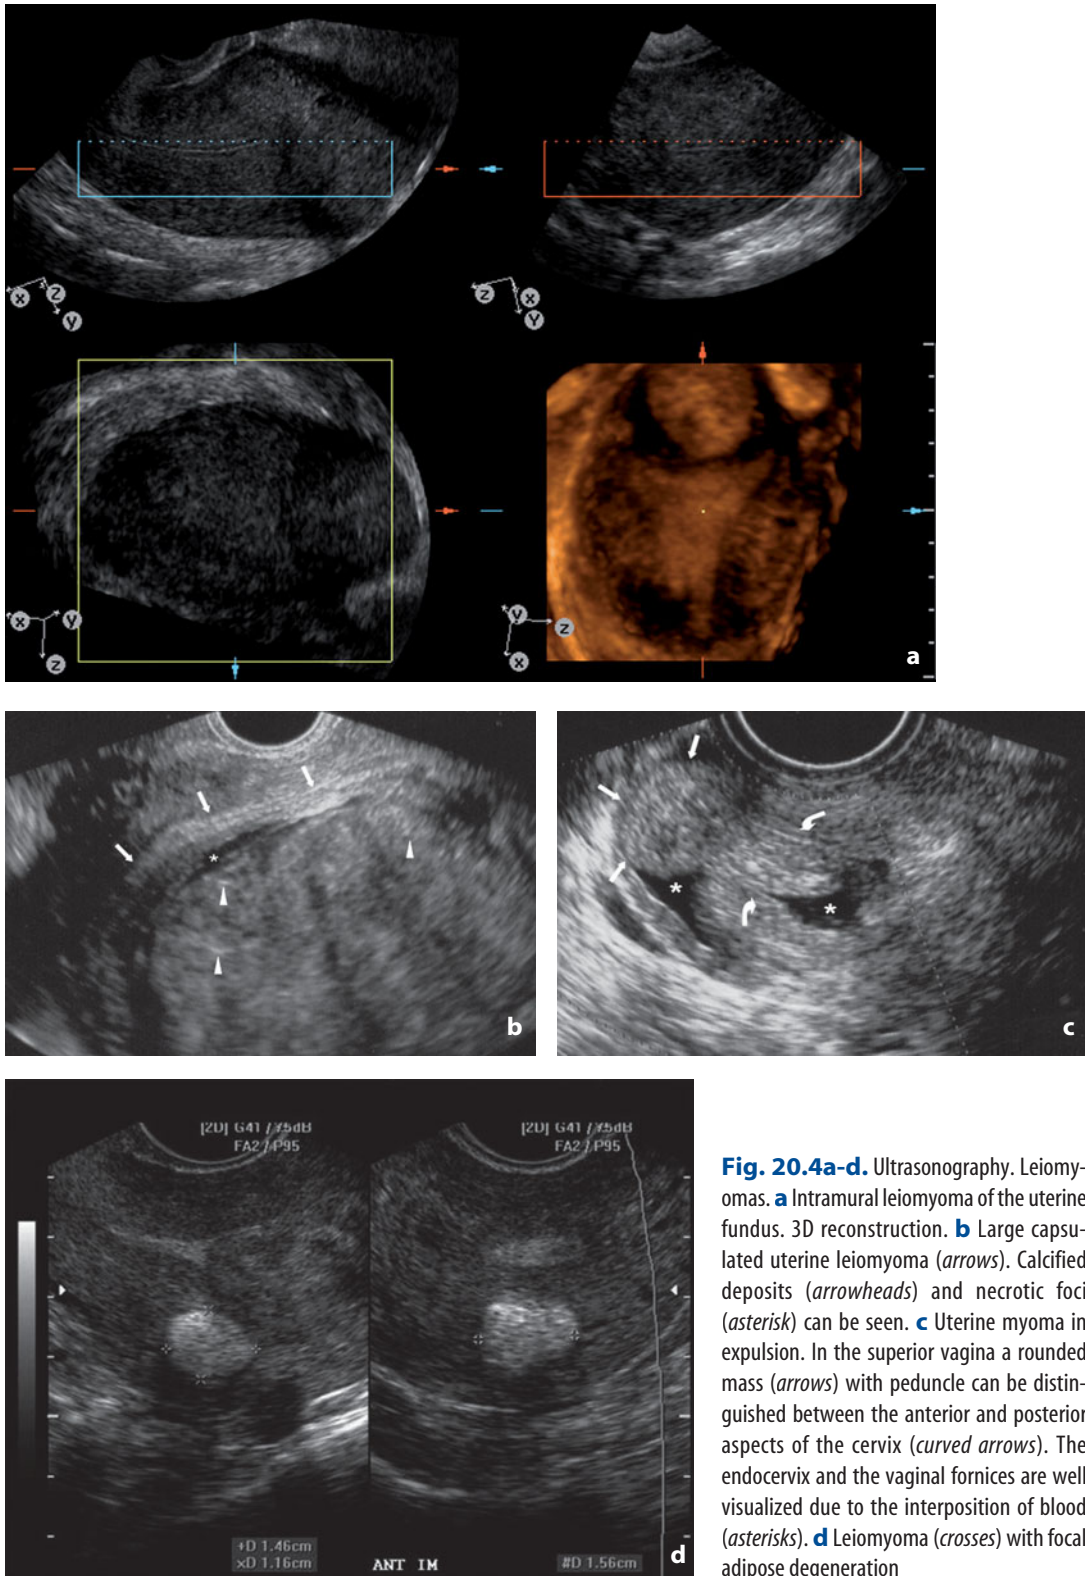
Ultrasonography. Leiomyomas. a Intramural leiomyoma of the uterine fundus. 3D reconstruction. b Large capsulated uterine leiomyoma (*arrows*). Calcified deposits (*arrowheads*) and necrotic foci (*asterisk*) can be seen. c Uterine myoma in expulsion. In the superior vagina a rounded mass (*arrows*) with peduncle can be distinguished between the anterior and posterior aspects of the cervix (*curved arrows*). The endocervix and the vaginal fornices are well visualized due to the interposition of blood (*asterisks*). d Leiomyoma (*crosses*) with focal adipose degeneration
